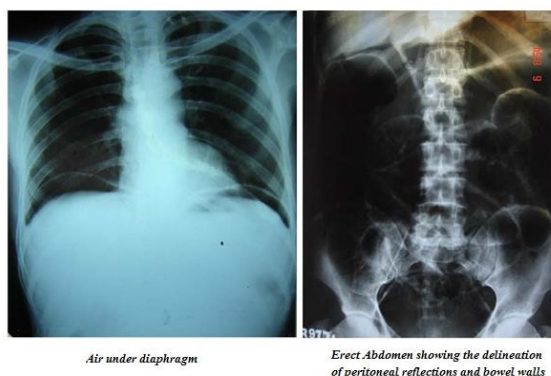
Plain radiography.
